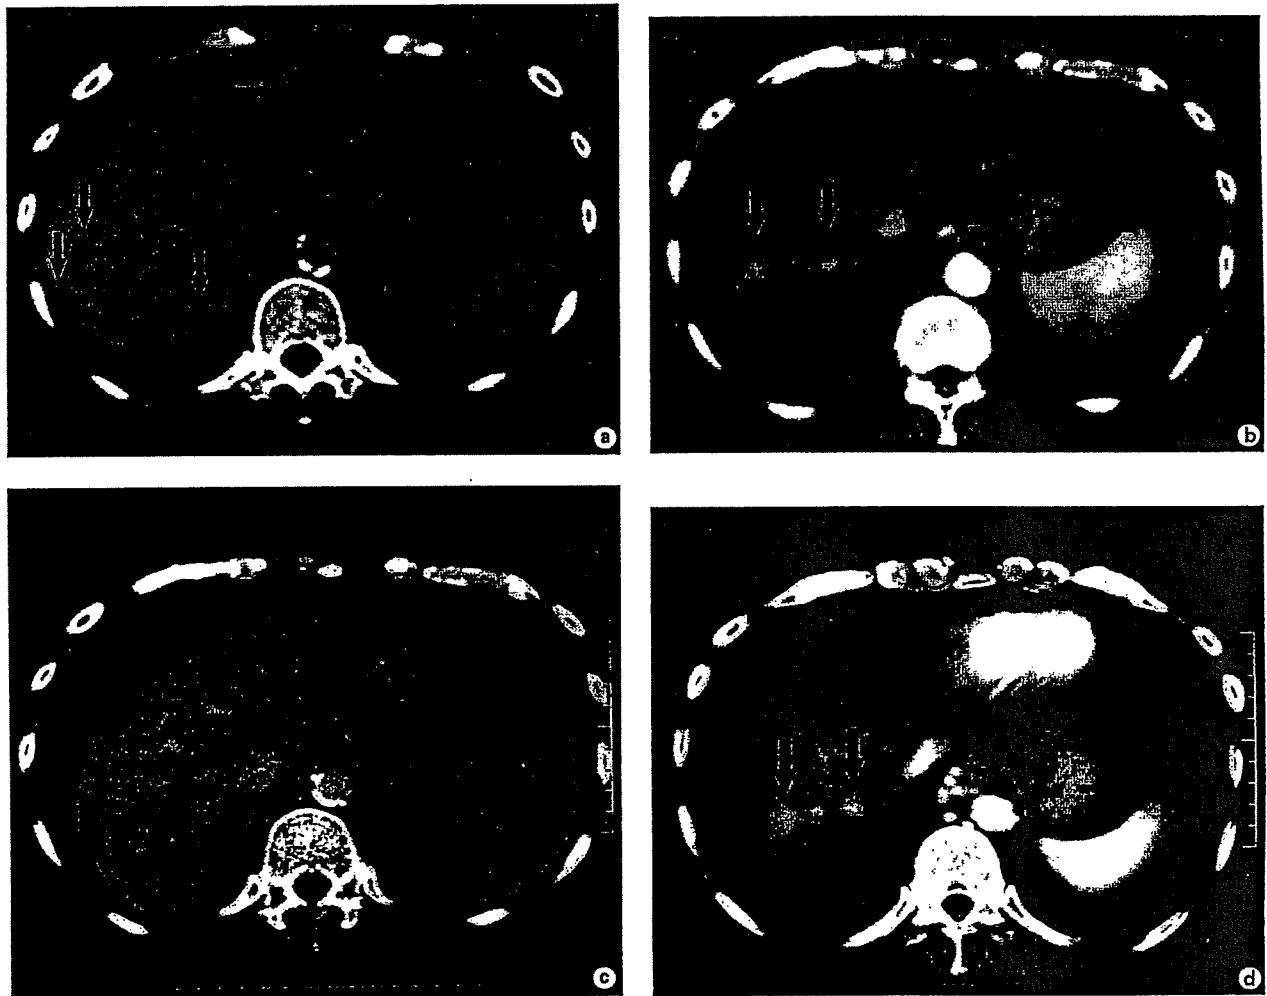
CT findings during the patient's recent course. a Contrast-enhanced CT in the portal phase showed multiple hypoattenuating tumors in the liver (vertical arrows). The horizontal arrow in the left lobe indicates an area of necrosis where RFA had previously been performed. b CT in the arterial phase showed two hyperattenuating tumors (arrows) in hepatic segment 8. c CT in the portal phase after THP-COP with rituximab showed disappearance or shrinkage of the hypoattenuating tumors shown in a. Marked ascites can also be seen. d CT in the arterial phase after THP-COP with rituximab showed no shrinkage of the two hyperattenuating tumors shown in b.
